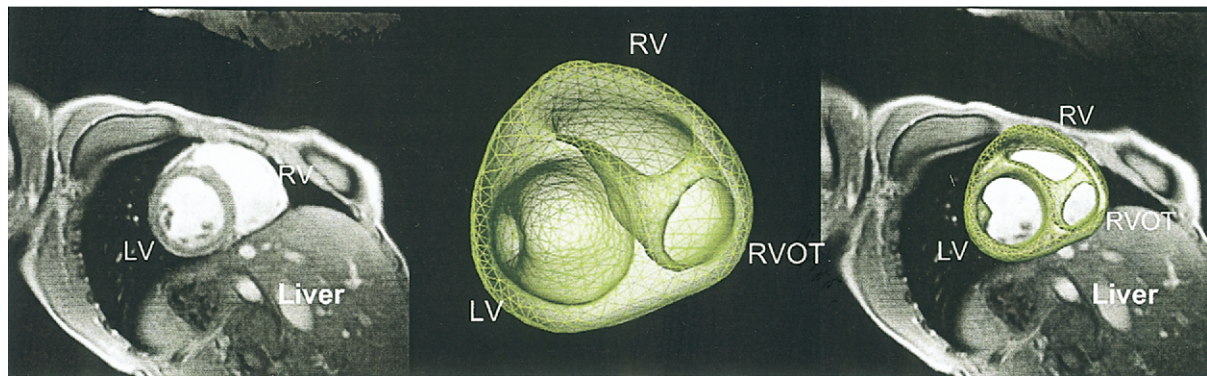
Ventricular surface model from a cardiac short-axis scan. The left panel shows a magnetic resonance imaging (MRI) slice (thickness 6 mm). The middle panel shows a triangulated and remeshed patient cardiac anatomy model with the left ventricle (LV), the right ventricle (RV), and the right ventricular outflow tract (RVOT). The right panel shows the fusion of MRI data and the cardiac anatomy model.
